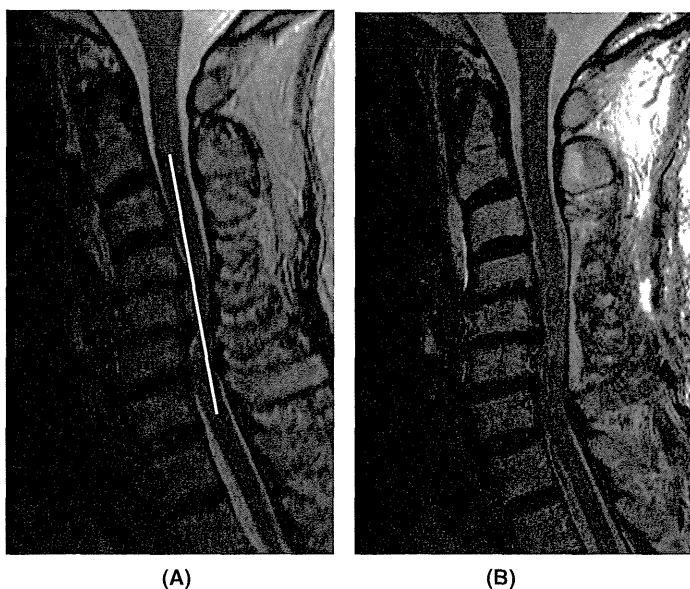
Preoperative magnetic resonance (MR) image shows severe compression of the cervical spinal cord at C4–C5 and C5–C6, and INT_{\min} was 0.9 mm at the C5–C6 level (A). Postoperative MR image 6 months after C3–C7 laminoplasty shows insufficient posterior shift of the cord and persistent anterior impingement of the cord at the C5–C6 level (B).
